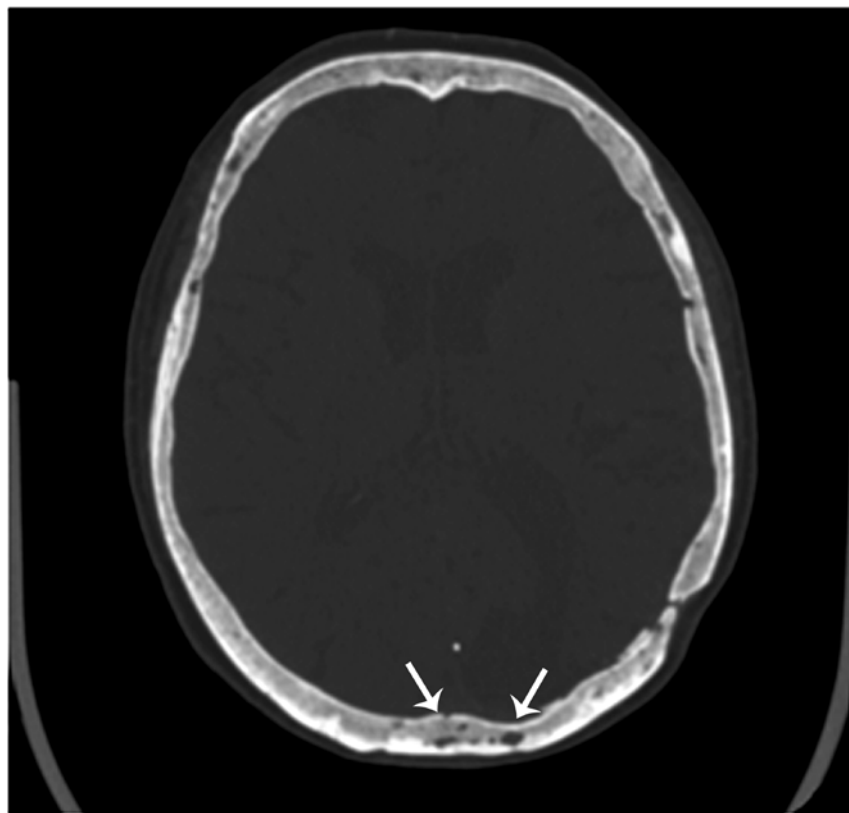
Identifying the signs of autologous flap osteolysis after osteoplastic craniotomy. Computed tomography image of the skull in the axial plane: A, 1 day after surgery; B, after 12 months. After 12 months, an area of marginal osteolysis of the bone flap is visible in the area of the burr hole, initially filled with OPM; there are signs of OPM lysis in the area of plastic surgery
